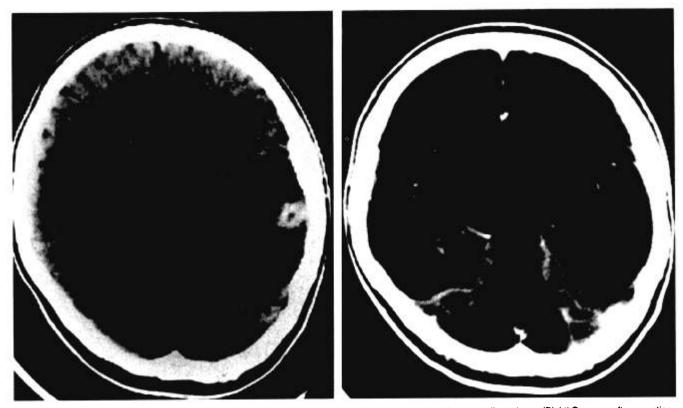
(Case 1) (Left) Preoperative CT scan with contrast enhancement shows left temporal mass with surrounding edema. (Right) One year after resection, CT scan shows only a small area of lucency.
